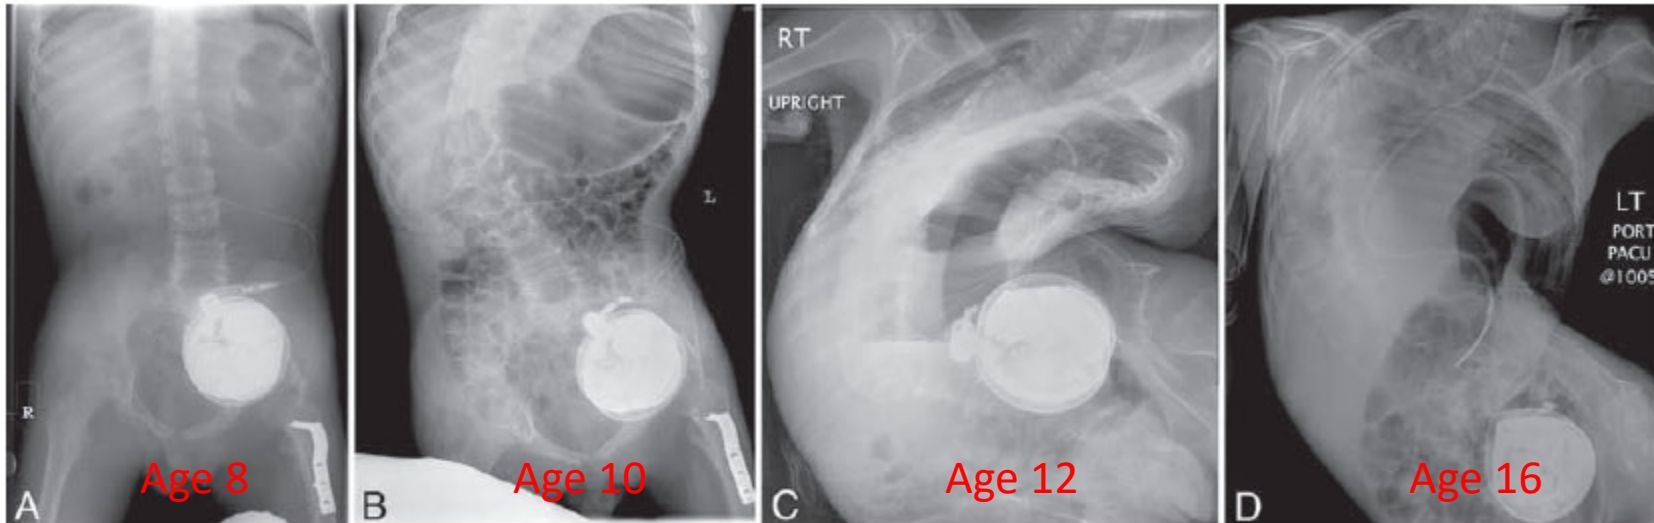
Case 9. Radiographs demonstrating development of scoliosis following baclofen pump insertion at 8 years of age: at 17 (A), 51 (B), 97 (C), and 118 (D) months after insertion of a baclofen pump.
